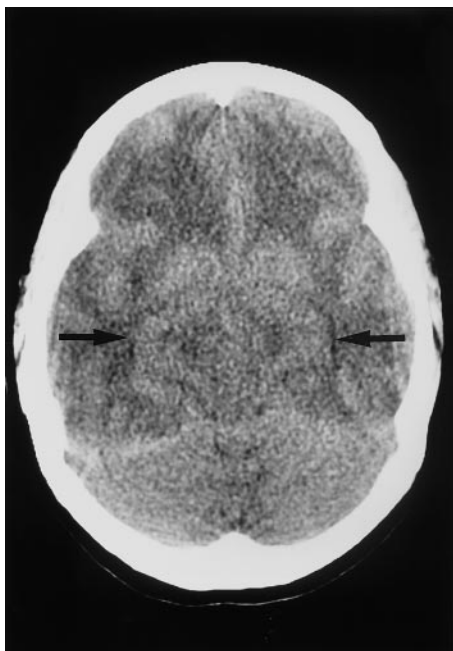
Head CT showing marked cerebral edema with almost complete obliteration of lateral ventricles (*arrowed*)
